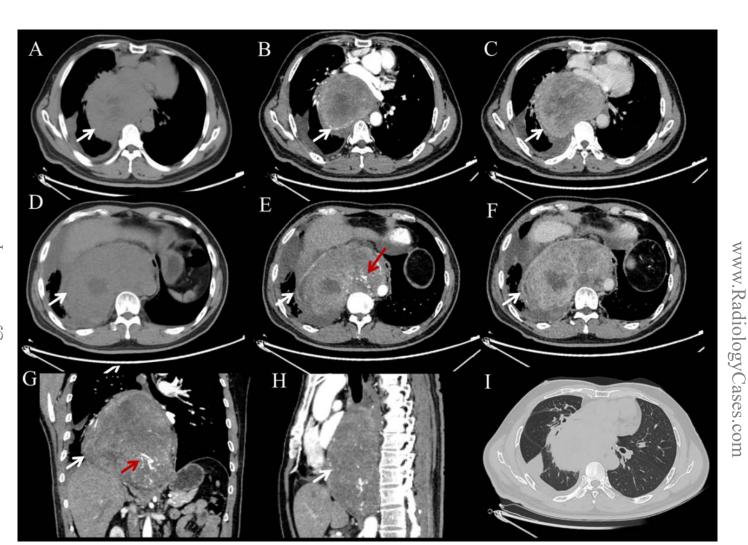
A: Non-contrast chest CT demonstrates a soft tissue mass located in the posterior mediastinum (white arrow indicates); B-C (Enhanced arterial and venous phases): The contrast-enhanced CT reveals a posterior mediastinal mass compressing the adjacent left atrium and pulmonary venous trunk (white arrow indicates); D: Non-contrast chest CT demonstrates a soft tissue mass located in the posterior mediastinum (white arrow indicates); E-H (Figures E, G and H show the arterial phase, while Figure F shows the venous phase): Contrast-enhanced chest CT (axial, coronal, and sagittal views) reveals a heterogeneously enhancing soft tissue mass in the posterior mediastinum (white arrow indicates), adjacent structures are compressed, and necrotic areas are observed within the lesion. Multiple small intralesional vascular structures are observed (red arrow indicates). The esophagus appears compressed and narrowed, and the interface between the lesion and the descending aorta is indistinct. I: Narrowing of a segmental bronchus in the right lung, accompanied by compression-induced consolidation and partial atelectasis.
